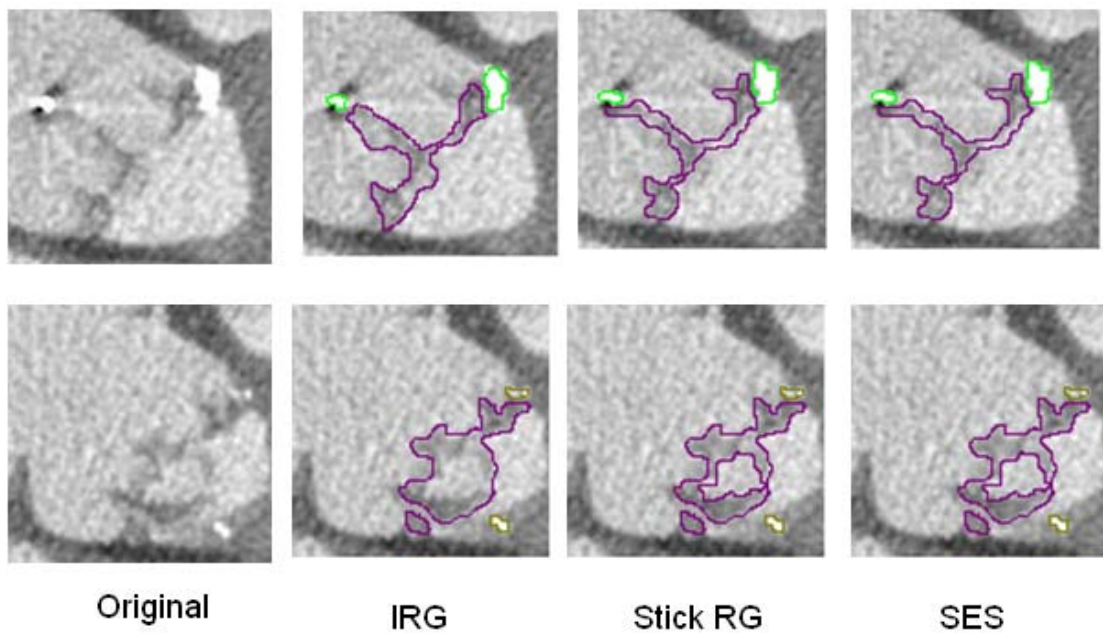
Examples of segmented CT-Slices obtained in case 4 - DAV: metallic stent, calcifications and leaflets are indicated by green, brown and purple border respectively.
